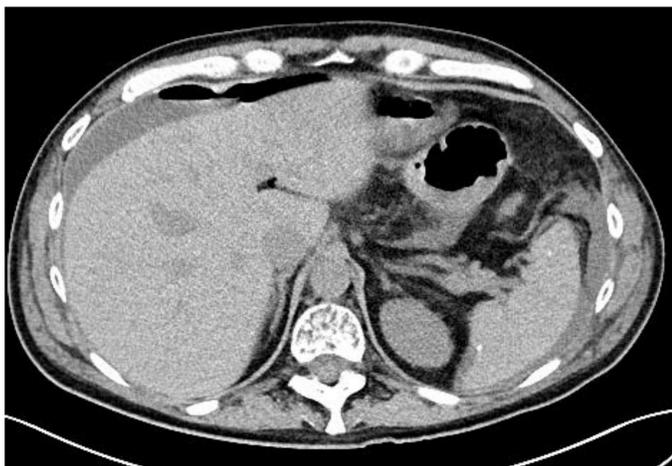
bowel perforation in a CT scan in one of the patients
